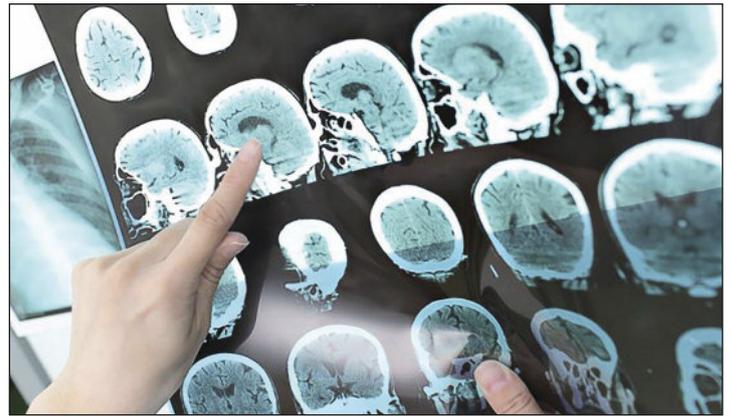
MRI scans should be avoided in COVID-19 patients (Photo courtesy of Shutterstock)
